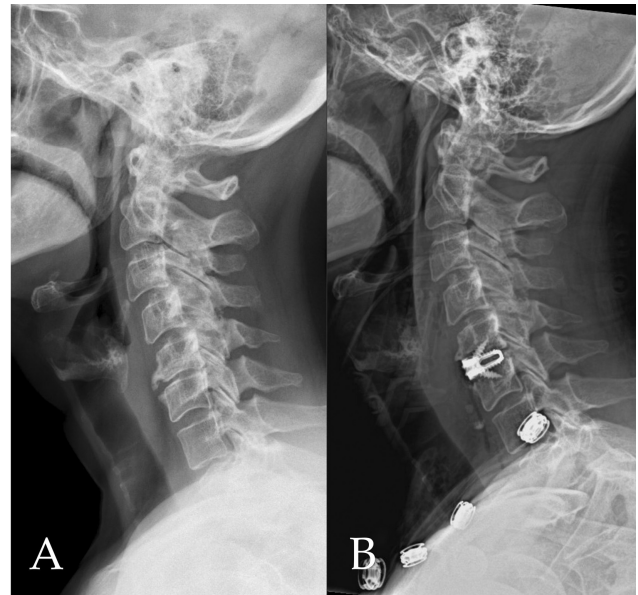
(A) Preoperative and (B) postoperative X-rays of patient 1 showing the C5-6 anterior cervical discectomy and fusion.
